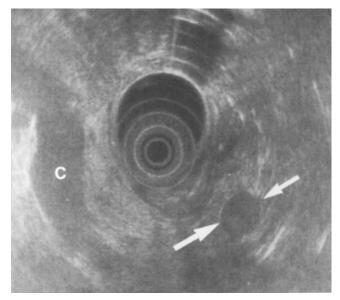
Endoscopic ultrasonographic image shows a wellcircumscribed, 1 cm hypoechoic mass in the pancreatic head (*arrows*). The probe lies within the second portion of the duodenum. Note the dilated distal common bile duct (C). Reproduced with permission from Buetow P. Islet tumors of the pancreas: clinical, radiologic and pathologic correlation in diagnosis and localization. Radiographics 1997;17:453–72. Copyright 1997 Radiologic Society of North America.
